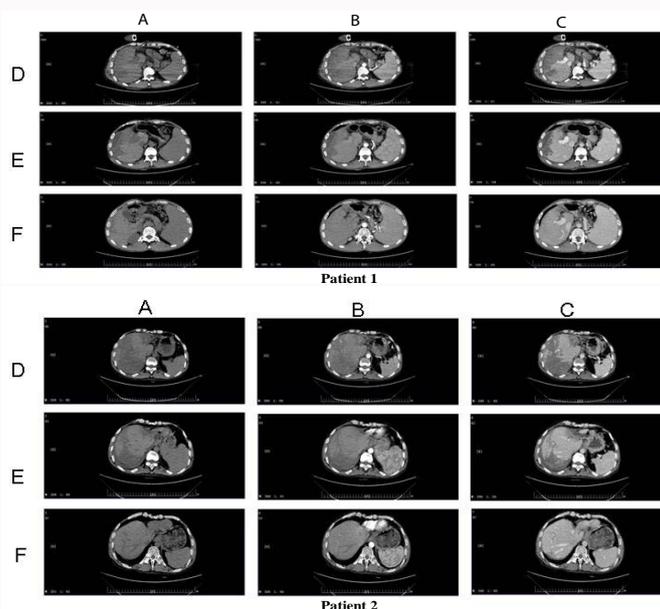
Abdominal CT scan shows a low-density area in the liver. A: hepatic equilibrium phase; B: hepatic arterial phase; C: portal venous phase. D: time of liver function deteriorated; E: 15 days after PHLF. F: 6 months after PHLF.
